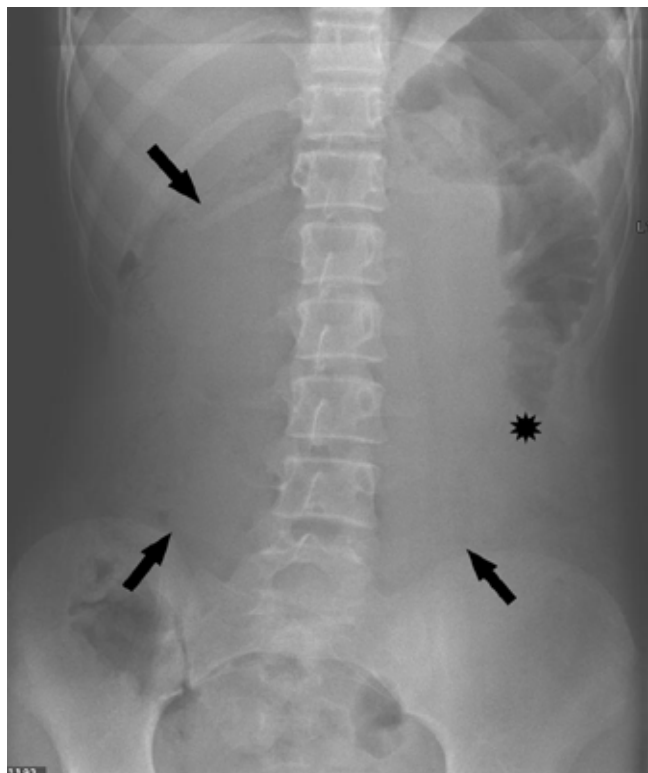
Abdominal radiograph demonstrating a large, central abdominal mass (arrows) and an associated high small bowel obstruction (asterisk).
